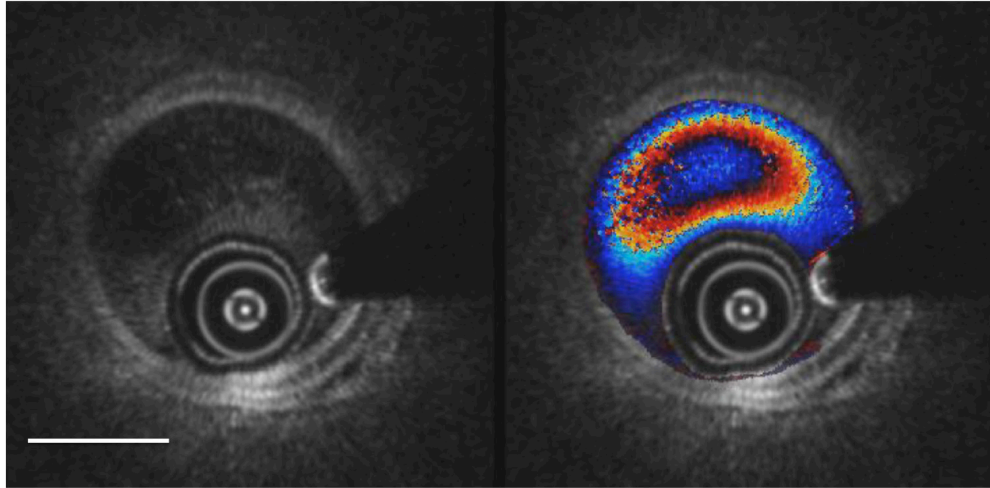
(Media 2) Simultaneous structural (left) and Doppler overlay (right) OCT video images (Media 2) over 2 seconds during the late phase of pump injection. Note the arterial pulsations in the structural images and the aliasing rings of the flow profile in the Doppler image. A seam line is moving through between the 11 o'clock and 2 o'clock positions, more apparent in the Doppler image than the structural. Scale bar = 1 mm.
